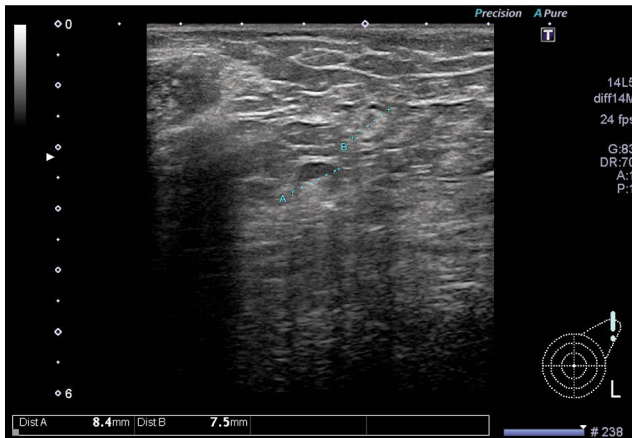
Ultrasonography (December 2020) shows axillary lymph node lengths of 8.4 mm and 7.5 mm, which were not suspicious of malignancy.
